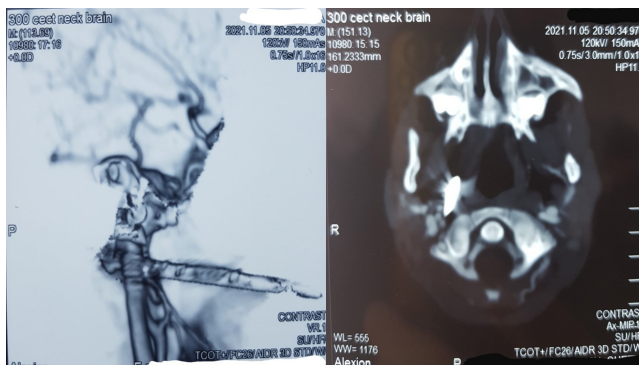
Pre-operative CT angiogram & CECT of the neck
